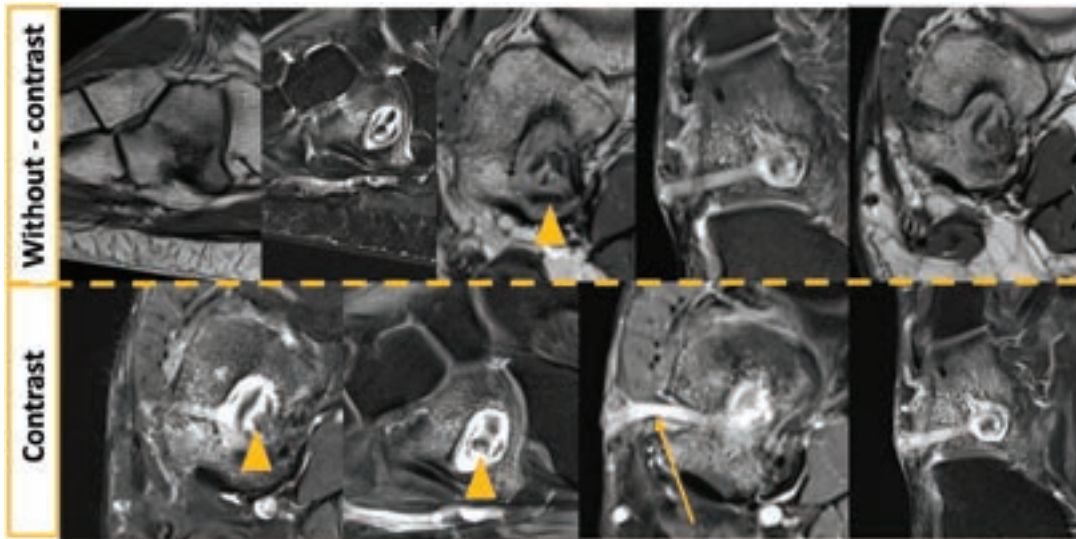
Pre-operative MRI imaging: The upper row shows images without contrast material, the lesion measured around 1.4 x 1.2 x 1.4 cm, it showed hypointense signal on T1 sequence and hyperintense signal on T2 with small central islands of hypodense lesions on both T1 and T2 suggesting sequestrum (arrow heads). The bottom row portrays images after contrast, there was hyperintense T2 signal with post-contrast enhancement except for the central small islands of sequestrum (arrow heads). There was a sinus track lesion extending from the central cavity to the plantar lateral skin (arrow).
